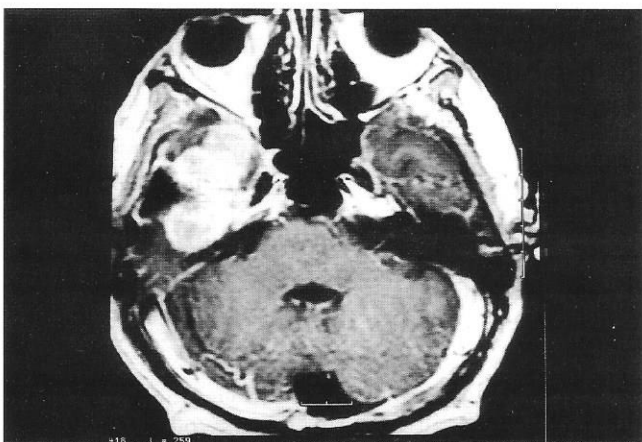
Magnetic resonance image showing tumor recurrence.
